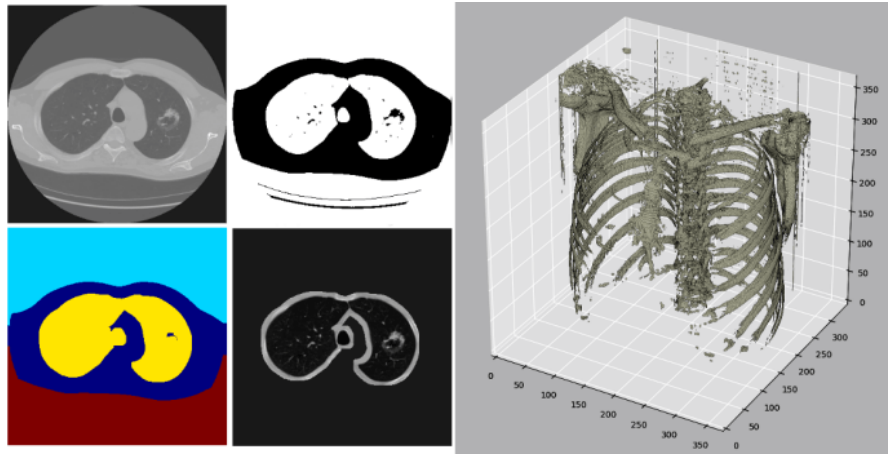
CT segmentation and 3D reconstruction steps. Image adapted from Howard Chen’s blog post *DICOM Processing and Segmentation in Python* [3].
